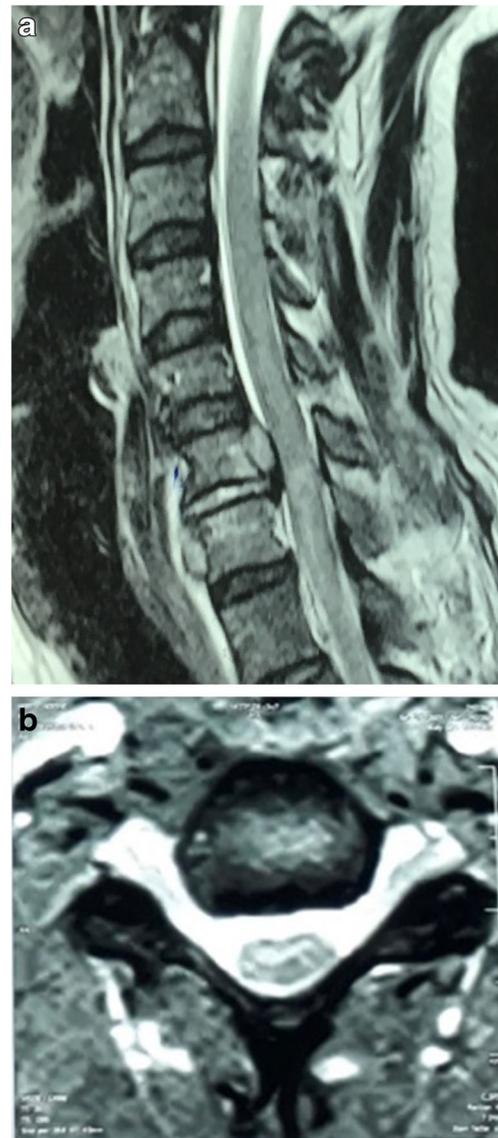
This figure shows T2 weighted sagittal (a) and transversal (b) MRI images of a 45-year-old patient ASIA's grade B. The scan revealed a free herniated C6-C7 disc into the spinal canal directly compressing the cervical spinal cord DECOULX grade D
